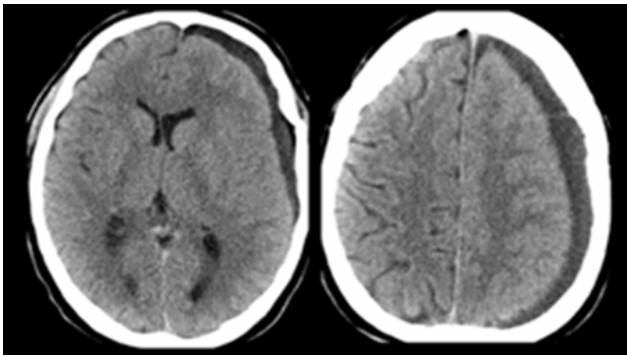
Brain CT after three weeks of acetazolamide treatment revealing enlargement of the left subdural hygroma
